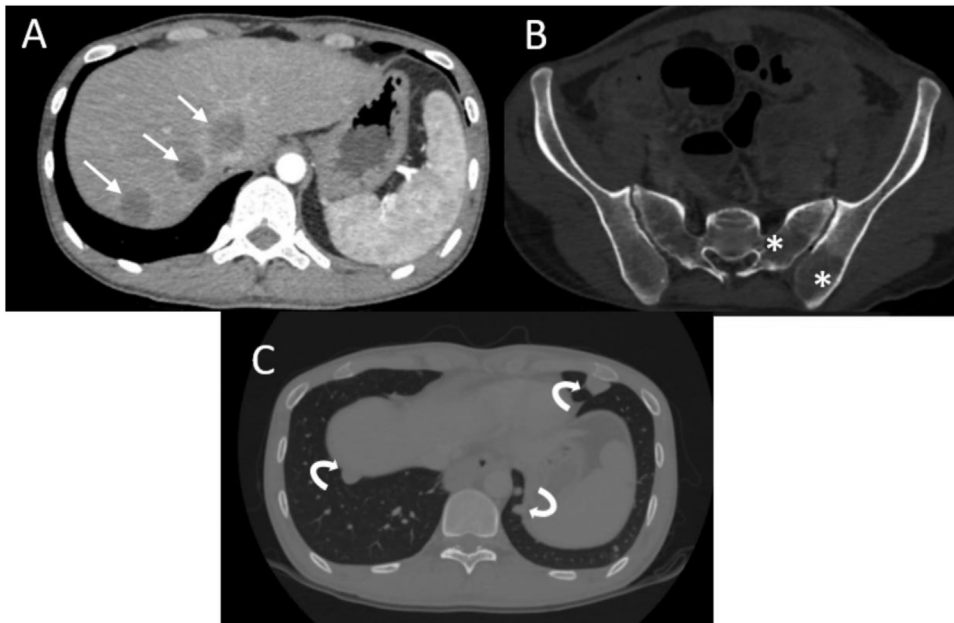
Abdominopelvic CT scan, axial abdominal window (A), axial bone window (B) and pulmonary window (C), several liver metastases (A- straight arrow), bone metastasis (B – asterisk), pulmonary metastasis (C- curved arrow).
